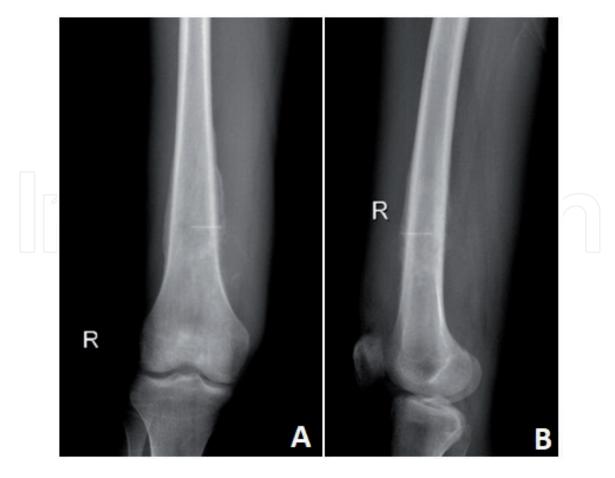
Right femur distal located osteosarcoma, a) anteroposterior and b) lateral radiography.*
